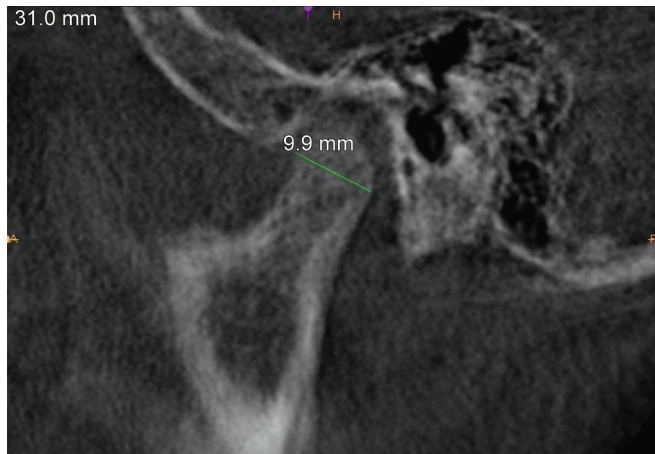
Cone-beam computed tomography (CBCT) scan of condylar length pretreatment
